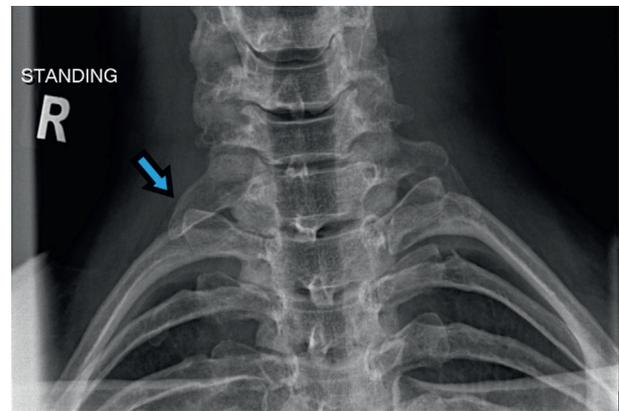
A plain X-ray of prominent C7 transverse process indicative of a fibrous band.
